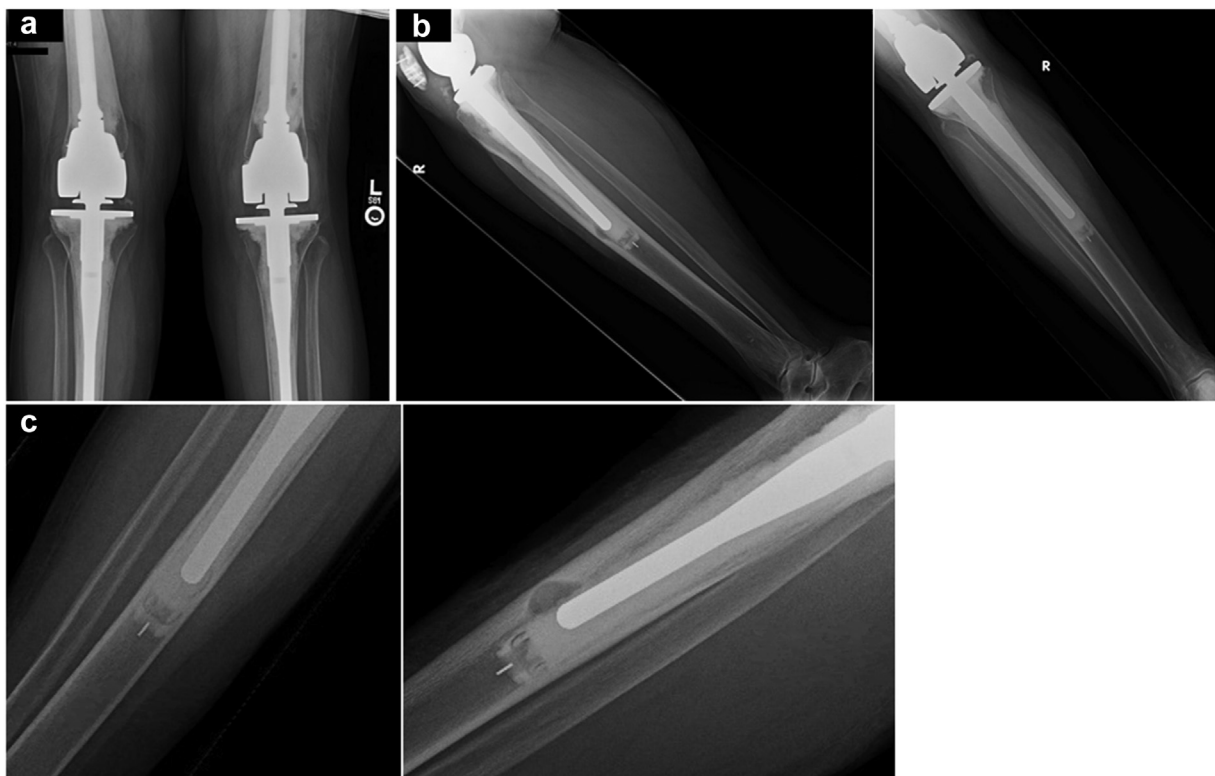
Five-year postoperative radiograph of revision right TKA. (a) Bilateral anteroposterior (AP) plain film of right and left hinged revision TKAs. (b) AP and lateral x-rays of the right tibia. (c) AP and lateral projections of distal stem tip in the right tibia. Mid-diaphyseal anterior tibial lesion can be seen at stem tip. Cement mantles other than the right tibial stem tip show no obvious erosions or debonding.
